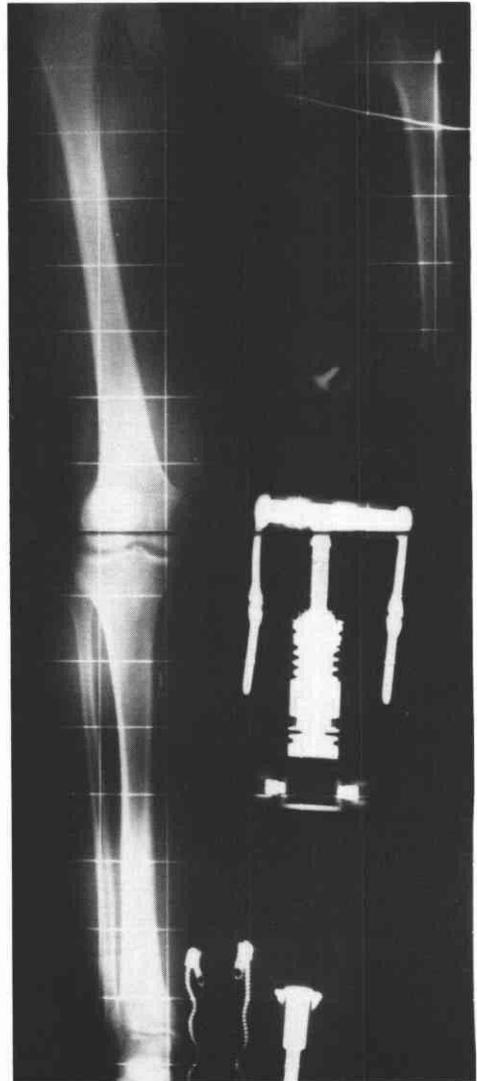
X-ray of standing patient showing relative abduction of amputated femur as compared to normal side.
